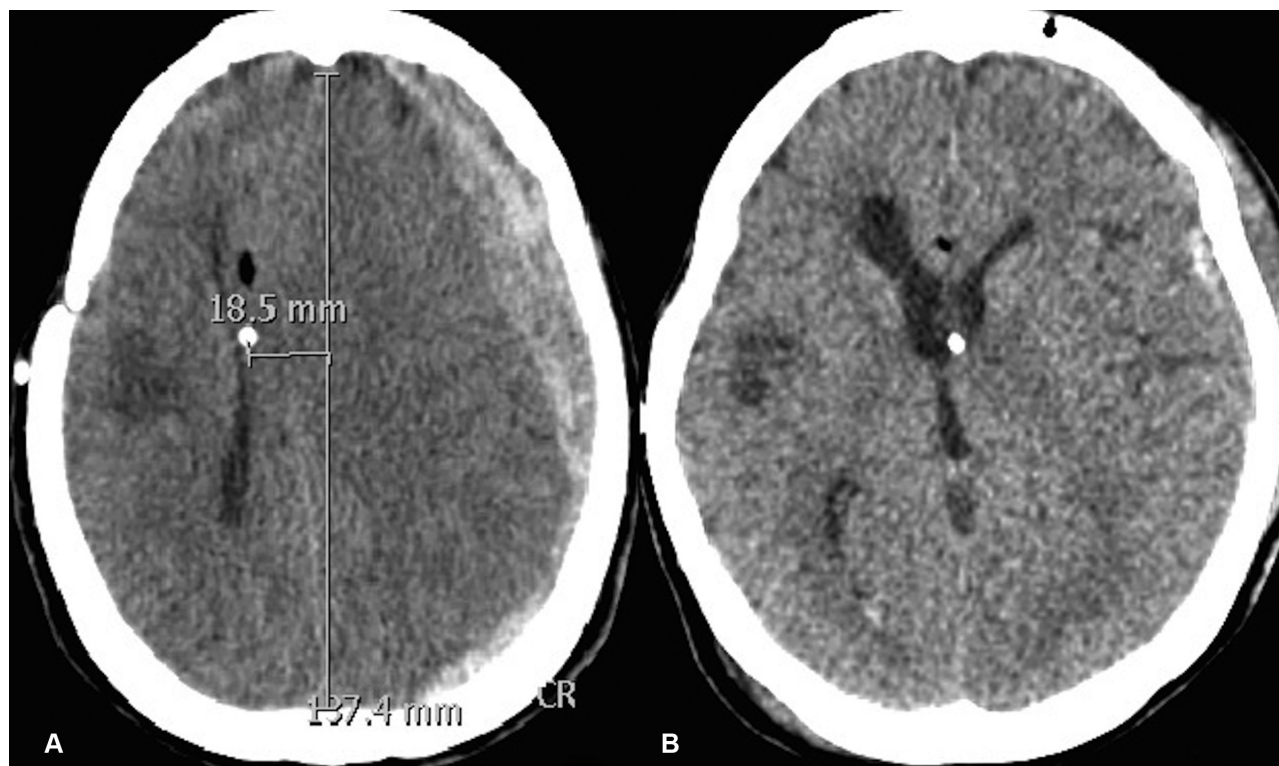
(A) Preoperative brain computed tomography disclosing huge left subdural hematoma and brain swelling with severe midline shift; (B) 24 hours postoperative brain computed tomography revealing brain swelling and midline deviation reduction.
